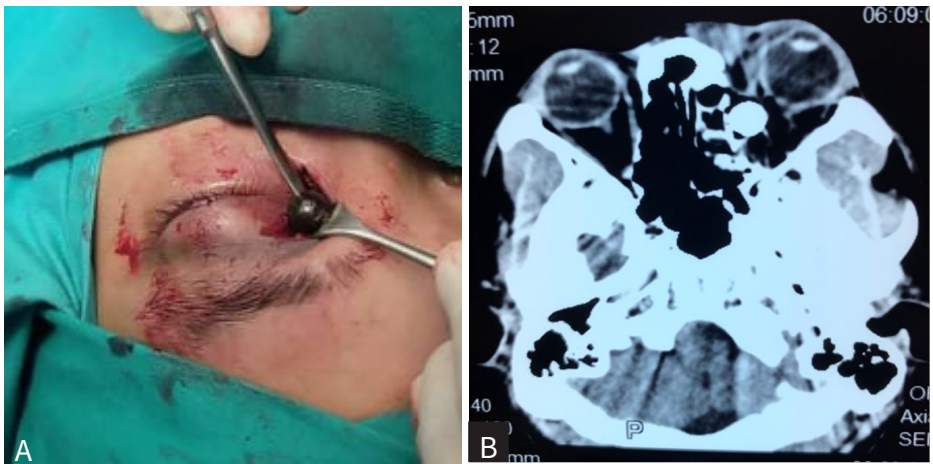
(a) Intraoperative finding of a metal ball removed from the orbit. (b) CT scan finding of a round foreign body located at the medial aspect of the left orbit towards the posterior medial wall.
